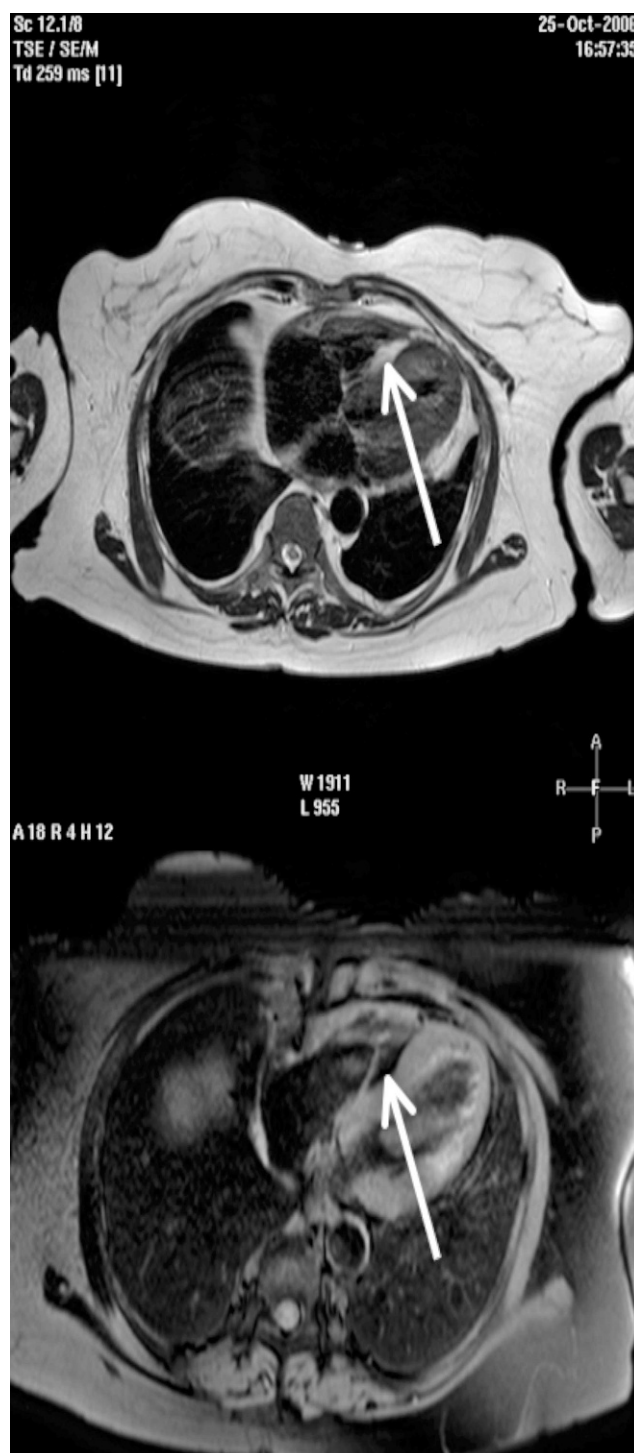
Case: 75-year-old female with a bright mass seen in the intraventricular septal on echocardiogram. Cardiac magnetic resonance imaging: Black blood imaging (top) and fat suppression (bottom). Diagnosis: Benign cardiac lipoma (arrows); mass disappears with fat suppression.
